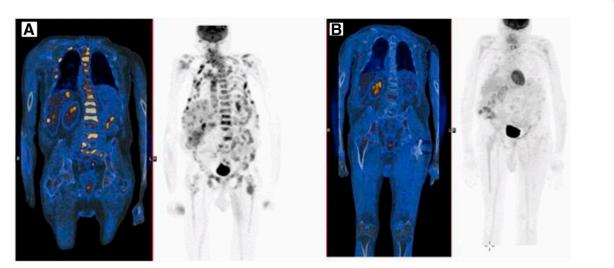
Positron emission tomography-computed tomography-selected coronal slices demonstrate multiple foci of pathological increased fludeoxyglucose (FDG) uptake in lytic and sclerotic bone lesions and in hypodense liver lesions (A) and significant improvement with few low-intensity foci of FDG uptake in the skeleton and no evidence of liver metastases (B) after 6 months of treatment.
